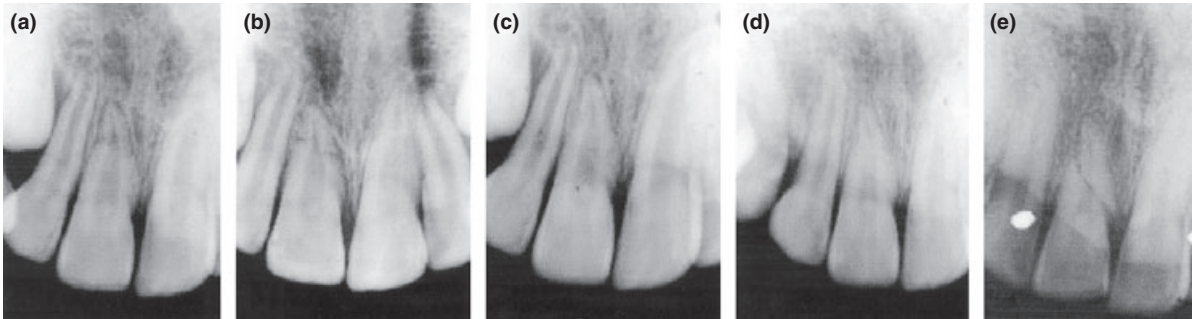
New luxation of the coronal fragment. (a) A mature incisor showing a fracture in the apical area of the root. (b–d) Radiographs taken 3, 16 and 42 months after injury show healing with fusion of the fragments. Three months after the last control a new luxation of the coronal fragment occurred and radiographs taken 7.5 years after initial injury show healing fracture with interposition of soft tissue and the line of new fracture which apparently differs from the previous one.
